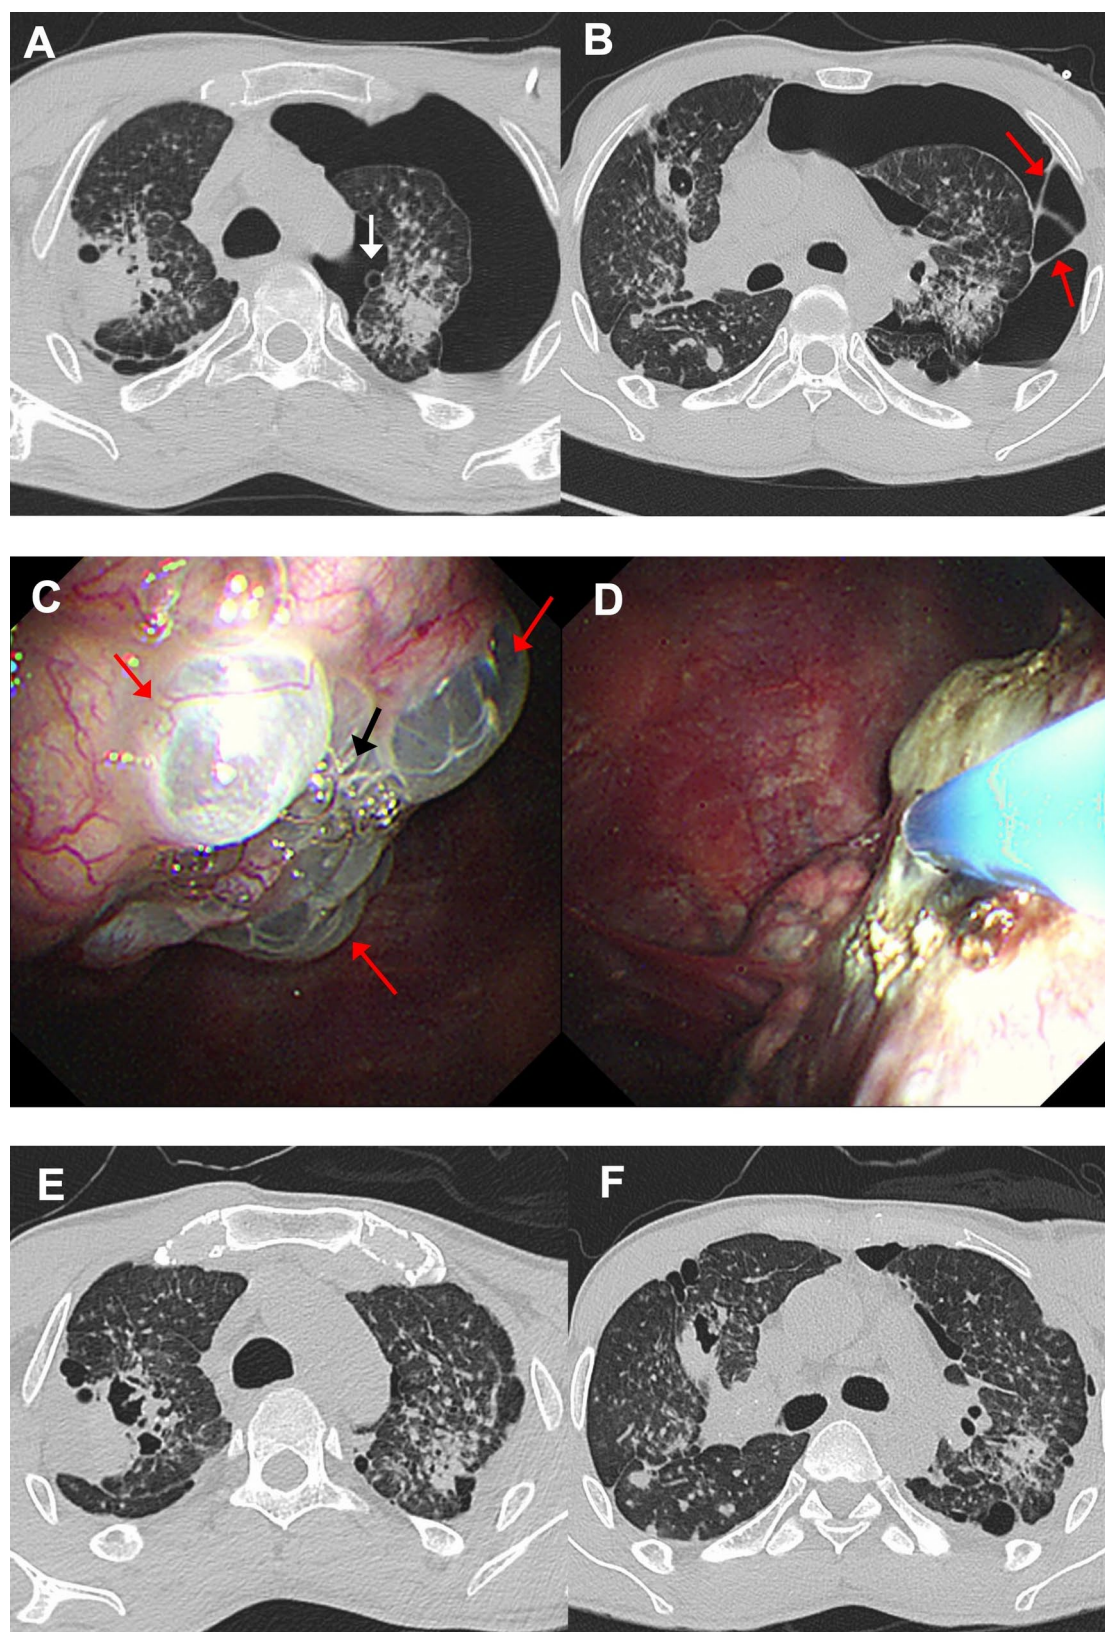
Patient No.2's MT procedure and preoperative/postoperative CT. A, B Preoperative CT, the white arrow indicates the pulmonary bulla and red arrows indicate pleural adhesions. C MT procedure, red arrows indicate pulmonary bullae and the black arrow indicates bubbles spilling out of the rupture. D MT procedure, cauterisation of the rupture and peripheral pulmonary bullae with APC. E, F Postoperative CT confirmed lung re-expansion. APC, argon plasma coagulation. CT, computed tomography. MT, medical thoracoscopy
